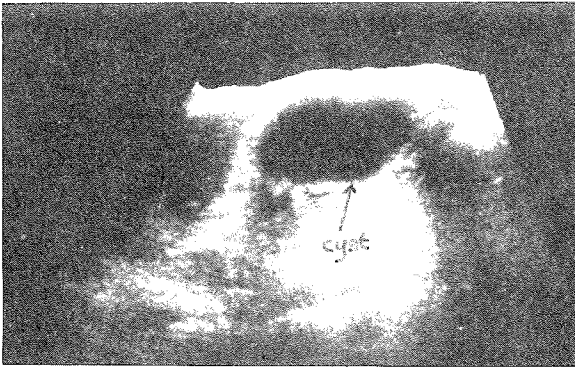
First ultrasound showing cyst lesion about 9.6 cm diameter (pre-drainage).
